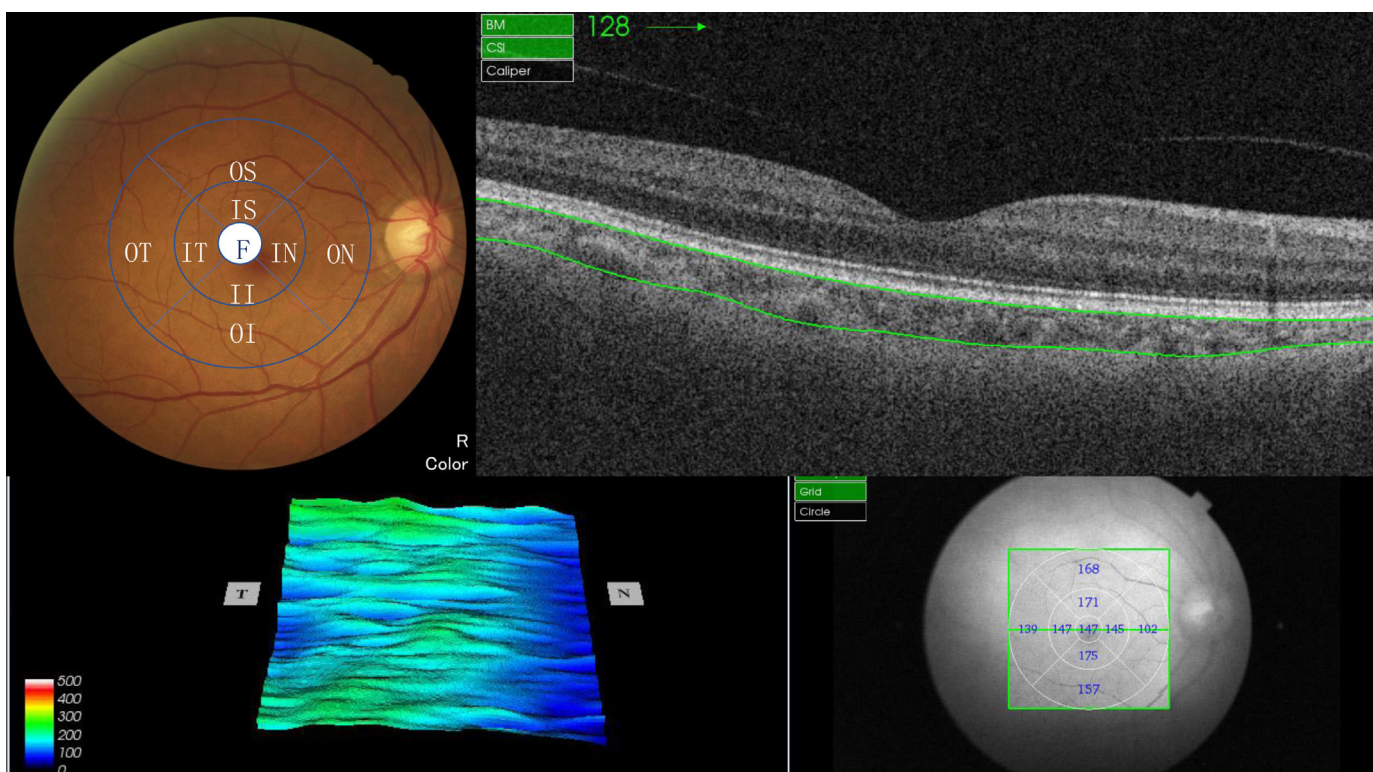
The swept source optical coherence tomography (SS-OCT) provides the measurements of choroidal thickness (CT) by automatically segmentation in 9 ETDRS grids. ETDRS, Early Treatment Diabetic Retinopathy Study; II, inner inferior; IN, inner nasal; IS, inner superior; IT, inner temporal; OI, outer inferior; ON, outer nasal; OS, outer superior; OT, outer temporal.
